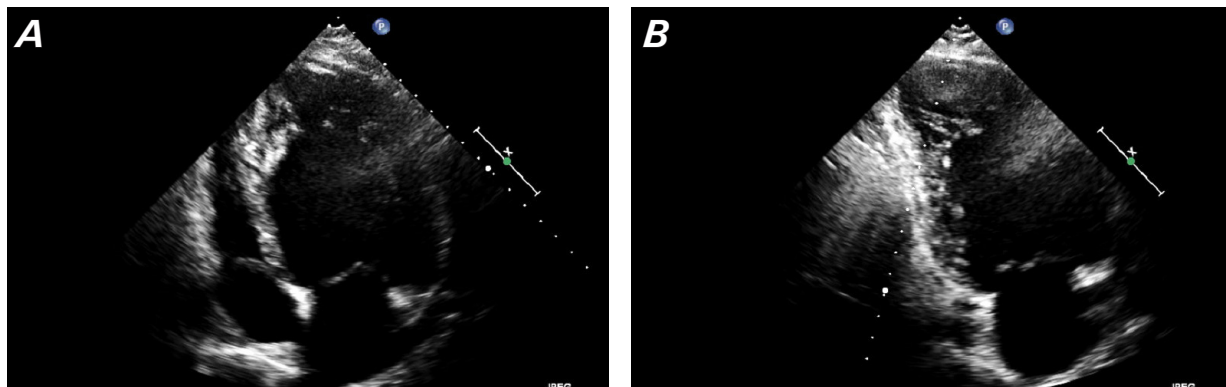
Transthoracic echocardiography shows a dilated left ventricle with spongiform appearance and prominent hypertrabeculations in lateral and apical walls in A) a 4-chamber view and B) a 2-chamber view.
